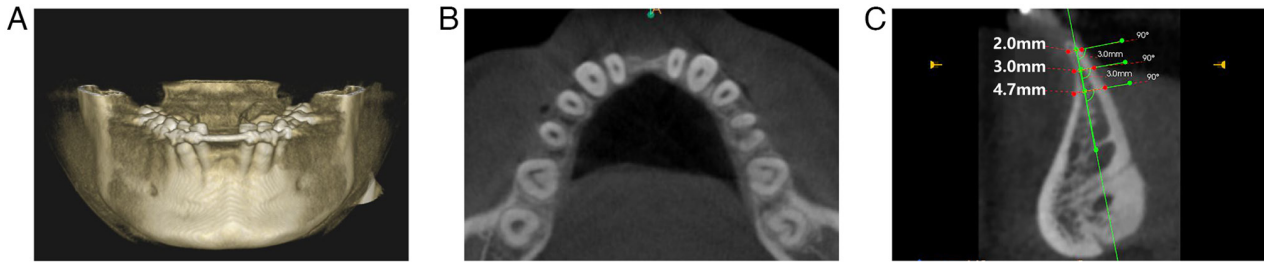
Preoperative bone width assessment by cone-beam computed tomography. (A) Three-dimensional reconstruction, (B) horizontal view and (C) sagittal view.
